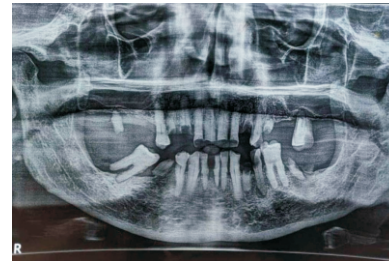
Orthopantomogram (OPG)
